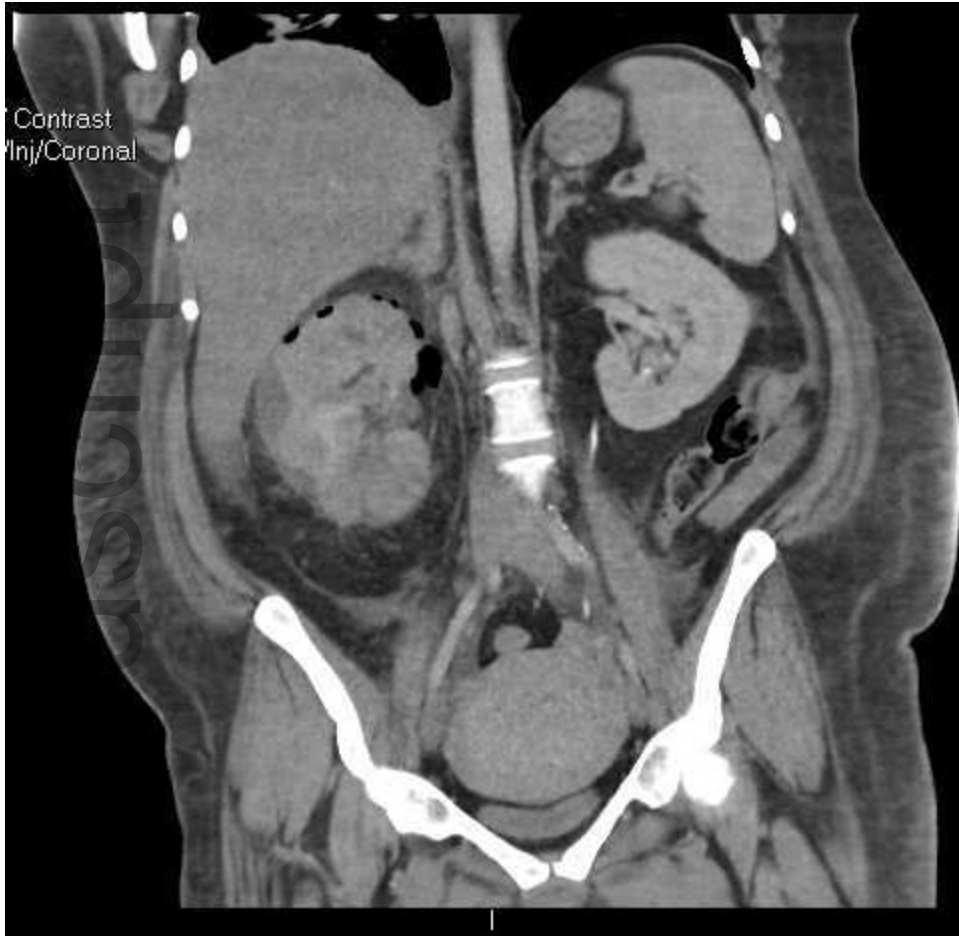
Coronal CT Abdomen Pelvis with IV Contrast in a Patient with Emphysematous Pyelonephritis
